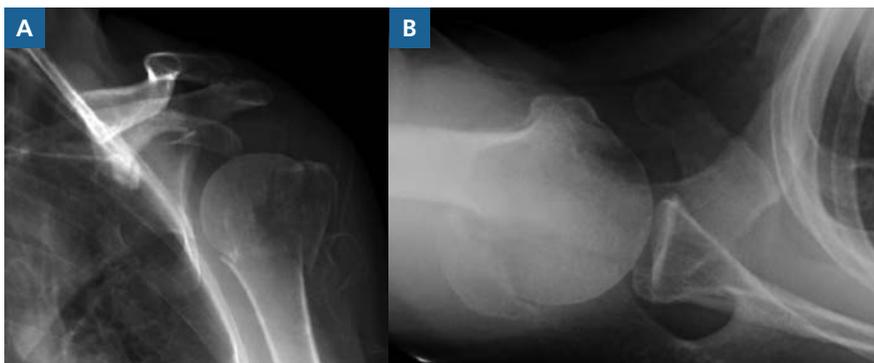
A, Anteroposterior (AP) and B, axillary radiographs of a 66-year-old woman with a greater tuberosity fracture and concomitant surgical neck fracture. Due to extensive medical comorbidities, she has been managed nonoperatively. As a result of the posterosuperior displacement of her greater tuberosity fracture, this patient has had limitations in shoulder abduction and external rotation.
